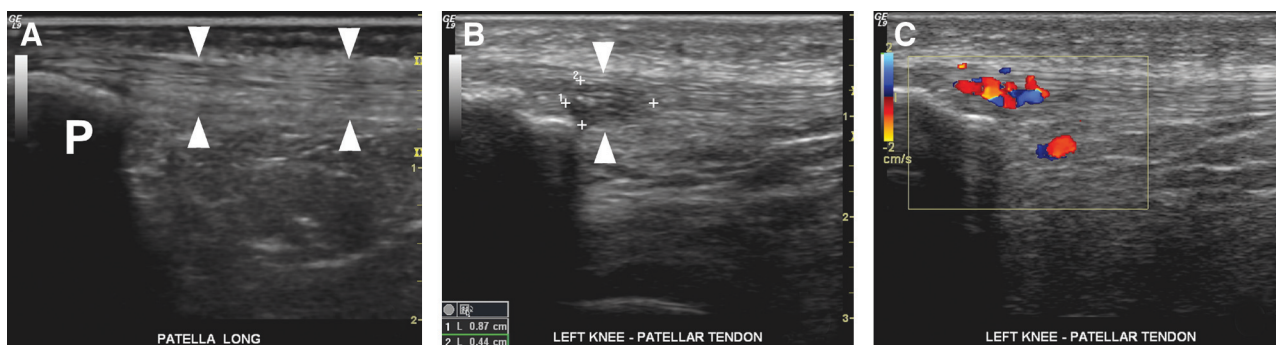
Ultrasonography images of the proximal patellar tendon in the longitudinal (sagittal) plane. A, asymptomatic 25-year-old male subject with normal gray-scale ultrasonography (GS-US) image at the level of the inferior pole of the patella (P). There is a normal fibrillar pattern within the tendon and the tendon has relatively uniform thickness in the anteroposterior direction (arrowheads). B, symptomatic 24-year-old male subject, imaged using GS-US. There is a wedge-shaped hypoechoic region at the inferior pole of the patella and increased tendon size in the anteroposterior direction (arrowheads), indicative of tendinopathy. C, same patient as B, imaged using color Doppler ultrasonography with a 20 × 16-mm region of interest placed over the proximal patellar tendon. Neovessels are present at the same location as the hypoechoic lesion identified using GS-US and along the posterior margin of the tendon.
